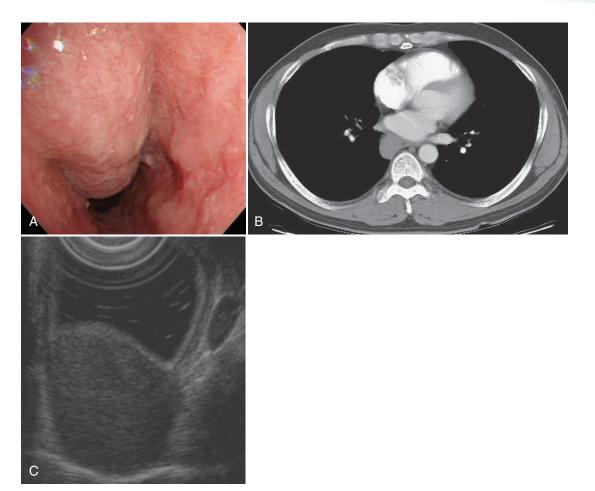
Bronchogenic cyst. A, Endoscopic view of a bulging mass lesion at the mid esophagus. B, The mass looks like a solid mass lesion on computed tomography. C, EUS demonstrates round homogeneous hypoechoic lesion in the mediastinum.
